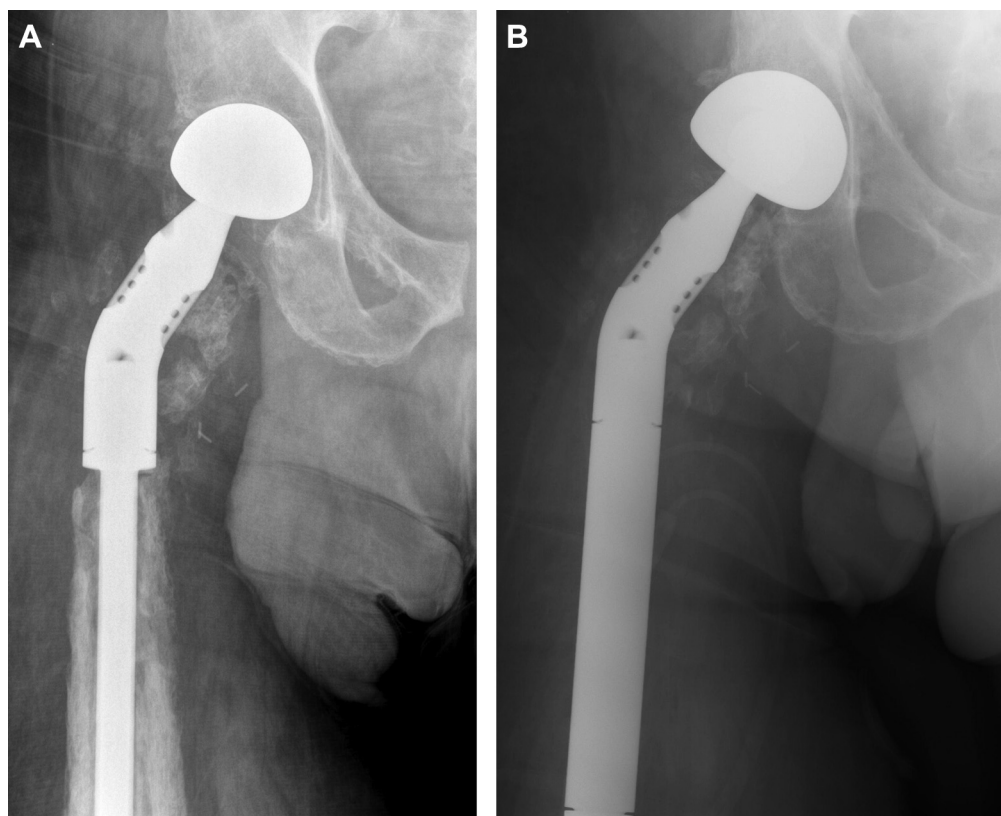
(A) Preoperative X-ray of a 62-year-old male with an infected proximal femoral arthroplasty used to treat a giant cell tumor of the proximal femur. This is the first case in this series. (B) Postoperative X-ray showing a monoblock dual-mobility shell used in this patient who is abductor deficient.
